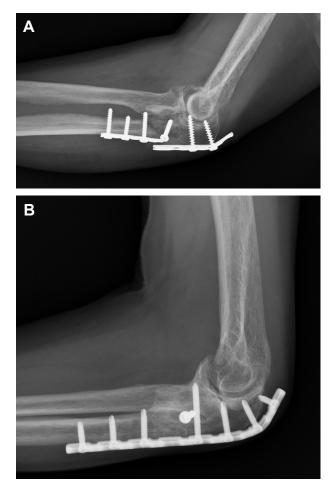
(A) A 80-year-old woman visited our out-patient clinic with broken plate. (B) The nonunion was repaired with a reconstruction locked plate and X-ray showed bone union with good alignment at one year.
